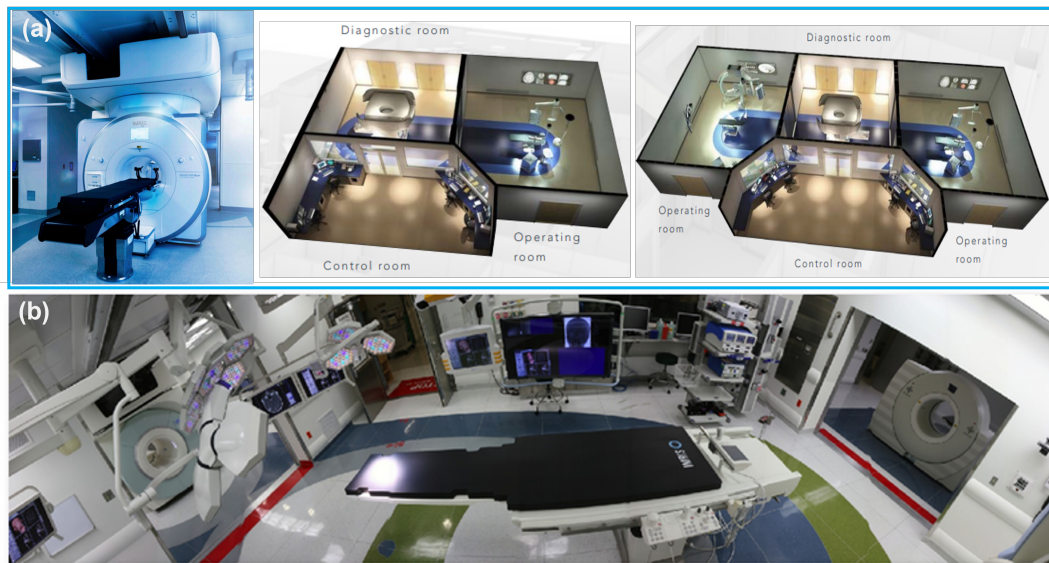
(a) IMRIS intra-op MRI suite with double-room or three-room configurations. Image source: [9]. (b) AMIGO operating suite combining MRI and PET/CT for image-guided therapy. Image source: [10].
